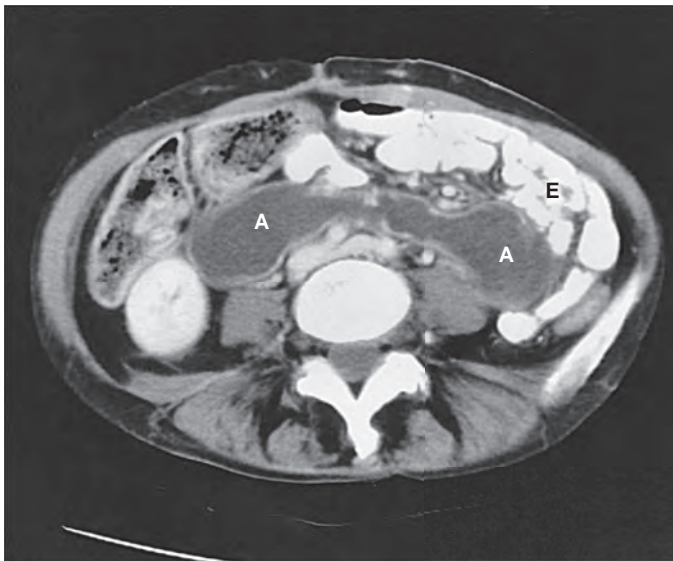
CT image of afferent loop obstruction. Oral contrast medium opacifies the normal efferent small bowel loops (E); the abnormal uniformly dilated afferent loop (A) remains nonopacified.
